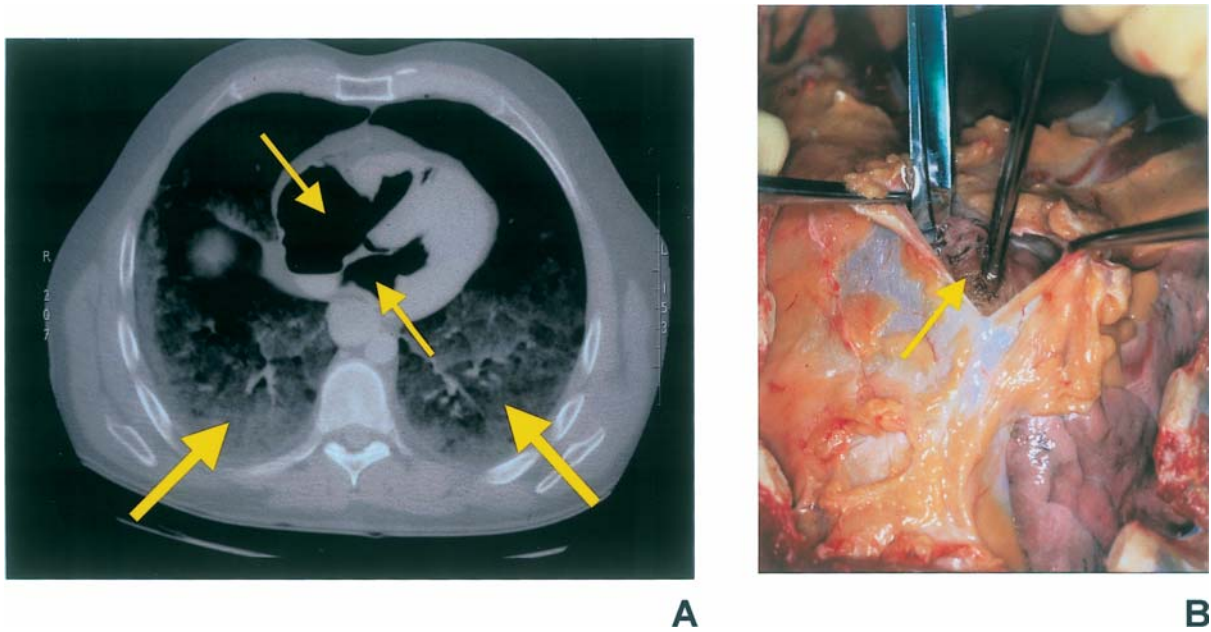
Suicidal gunshot wound of the head (Case 031): (a) biventricular air embolism (thin arrows) with patent foramen ovale; axial CT image also showing internal livores and hypostatical edema in both lungs (bold arrows); (b) Richter Test showing escaping air bubbles (arrow) after puncture of the right ventricle; this is the method conventionally used for demonstrating air embolism in the heart.
